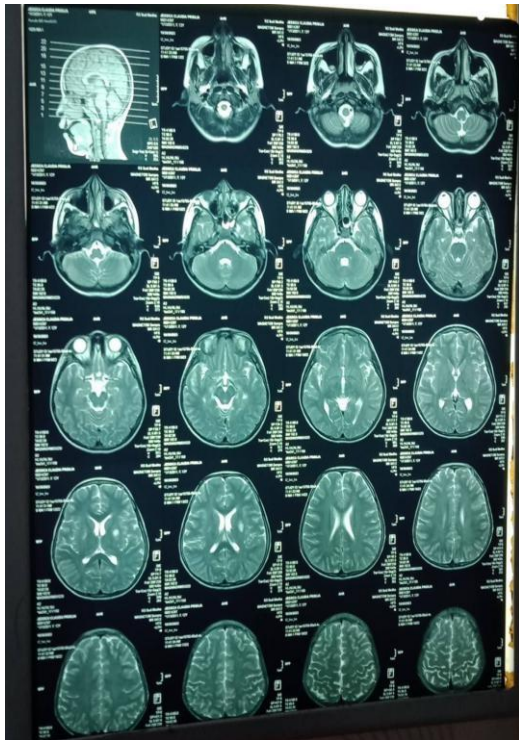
Brain MRI of the patient showing an abnormality
